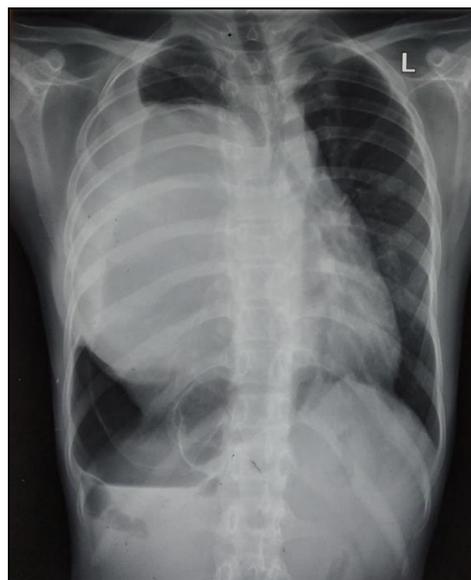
Postero-anterior chest radiograph demonstrating large homogenous opacity in right lung with right hydropneumothorax
